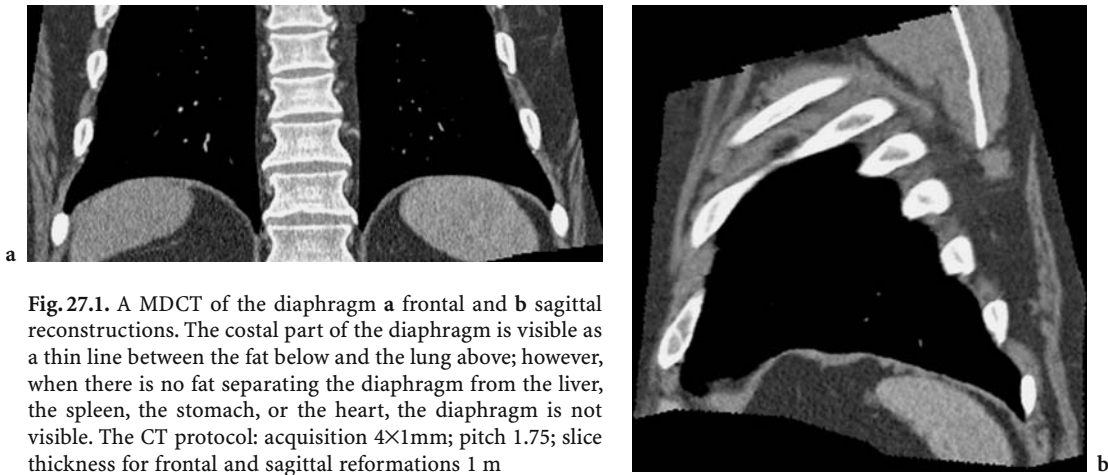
A MDCT of the diaphragm a frontal and b sagittal reconstructions. The costal part of the diaphragm is visible as a thin line between the fat below and the lung above; however, when there is no fat separating the diaphragm from the liver, the spleen, the stomach, or the heart, the diaphragm is not visible. The CT protocol: acquisition 4×1mm; pitch 1.75; slice thickness for frontal and sagittal reformations 1 mm
